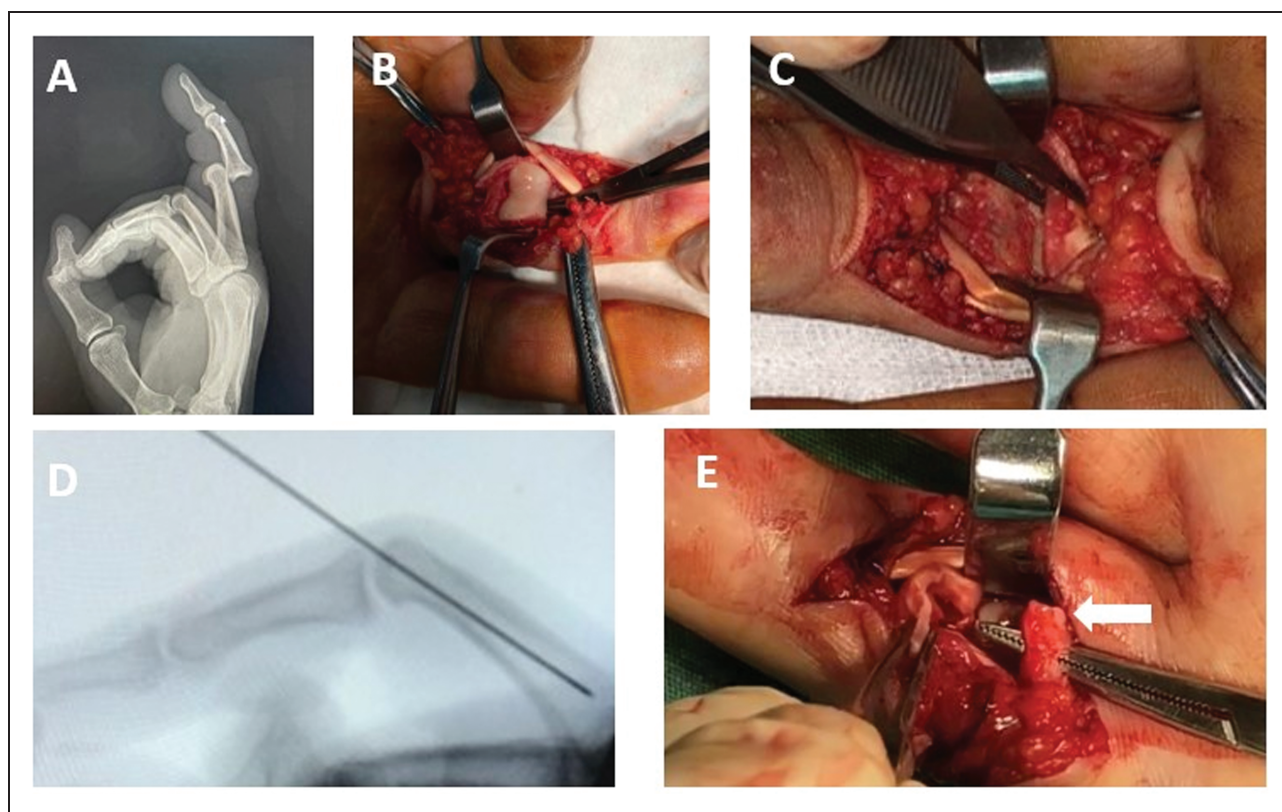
(a) Lateral radiograph of a dorsal proximal interphalangeal (PIP) joint dislocation without fracture. (b) An anterior Bruner skin incision is used. The flexor tendon sheath is opened and the flexor tendons retracted, revealing the dislocated PIP joint. The dislocated joint is approached between the ulnar and radial slips of the flexor digitorum superficialis (FDS), and fibrotic tissues that prevent reduction are released. (c) Controlling the volar plate tension with forceps after PIP reduction. (d) Extension block with a K-wire after PIP reduction. (e, f) If it is possible to fix the volar plate to the base of the middle phalanx base (white arrow), where it is detached, it is fixed with an anchor. If this is not possible, a volar plate reconstruction is done using an intact slip of the FDS tendon through the volar plate and (g) Concentric reduction seen in a radiograph at the final visit.
